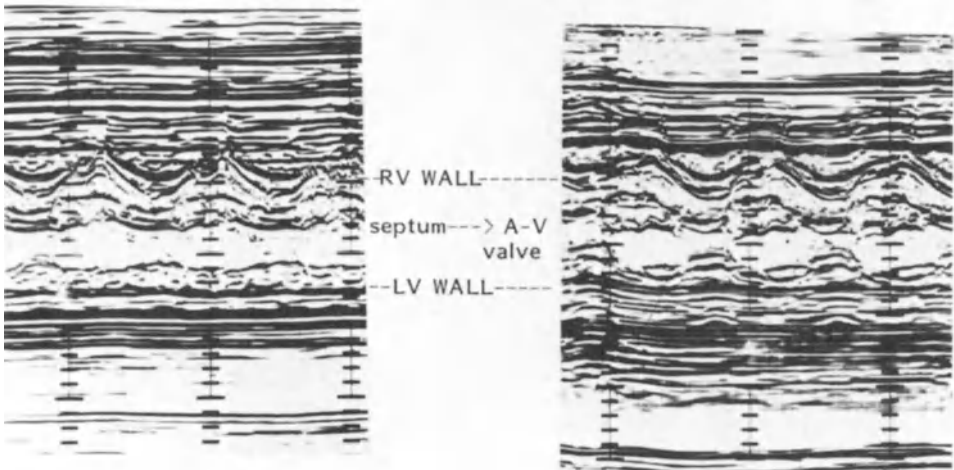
M-mode echocardiogram confirming the diagnosis of a common atrioventricular valve. Sweep from body of ventricles to A-V junction
